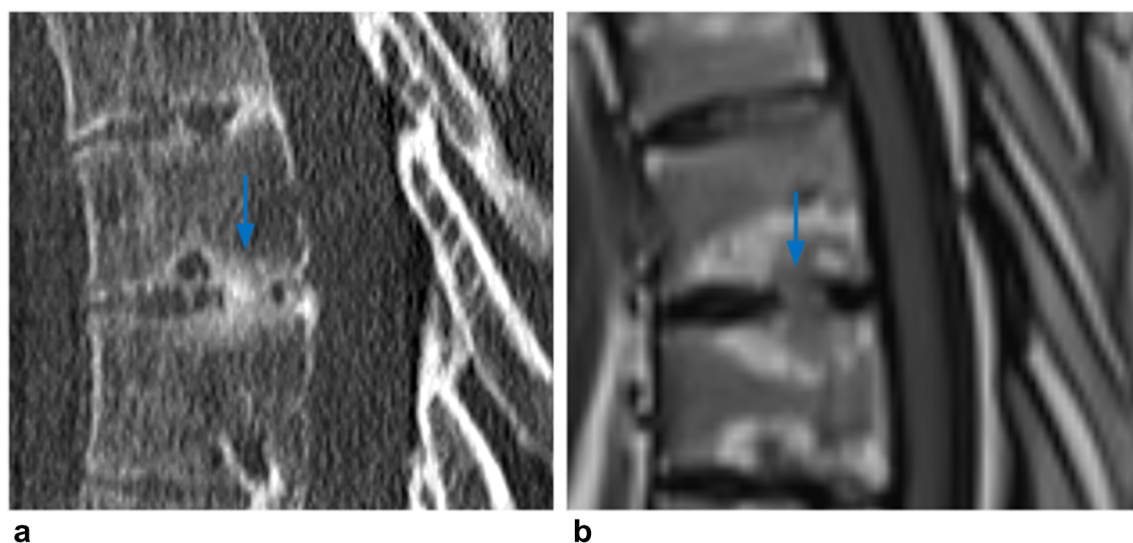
A 41-year-old man with ankylosing spondylitis. a, b Sagittal CT (a) and T1-weighted MR (b) images of the thoracic spine demonstrate transdiscal ankylosis
